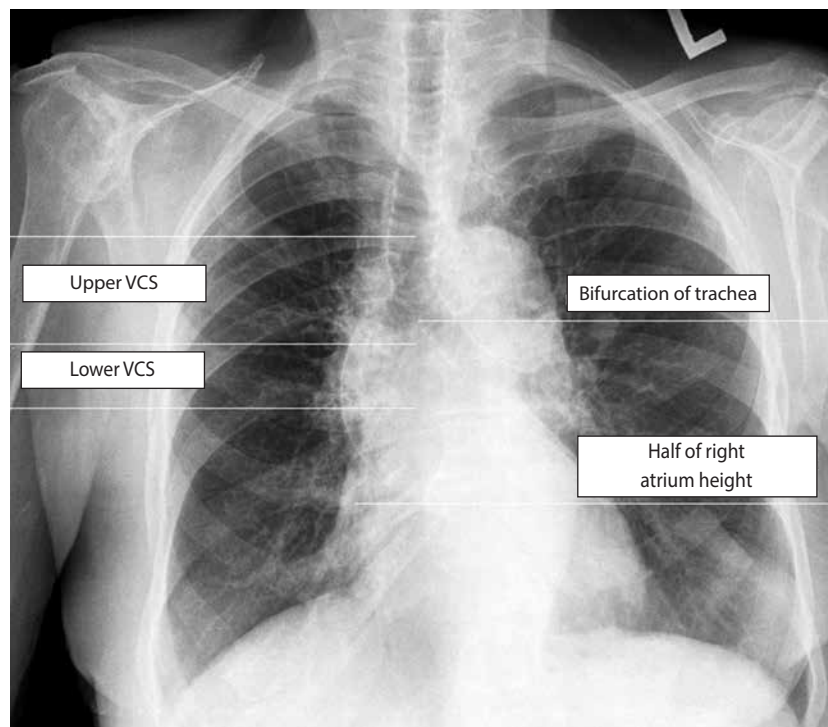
Chest X-ray showing zones of appropriate positioning of the catheter tip (description in the text)
